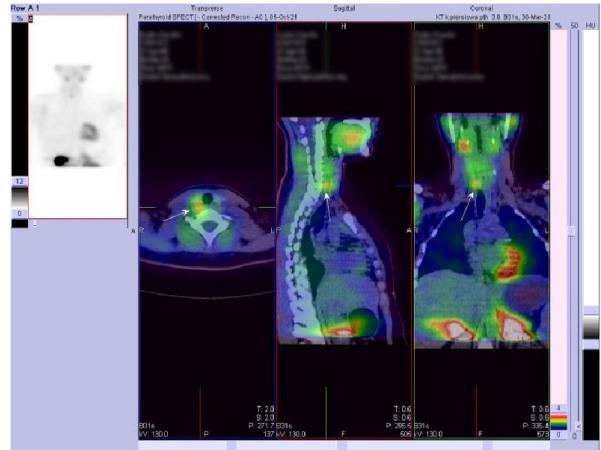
Scintigraphic examination of the parathyroid glands (planar + SPECT/CT). The arrow marks the focus of intense Technetium (^{99m}Tc) sestamibi uptake in contact with the lower pole of the right thyroid lobe
